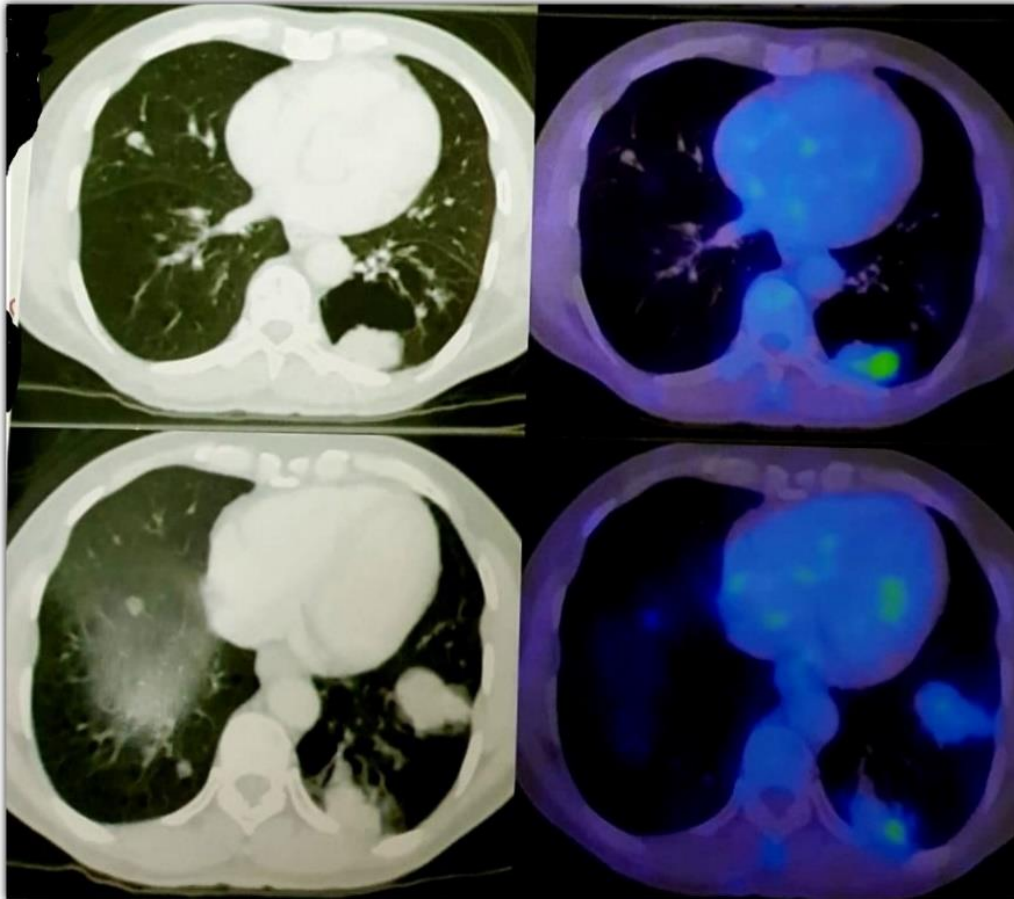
FDG PET CT showing good response at 24 months on Osimertinib
